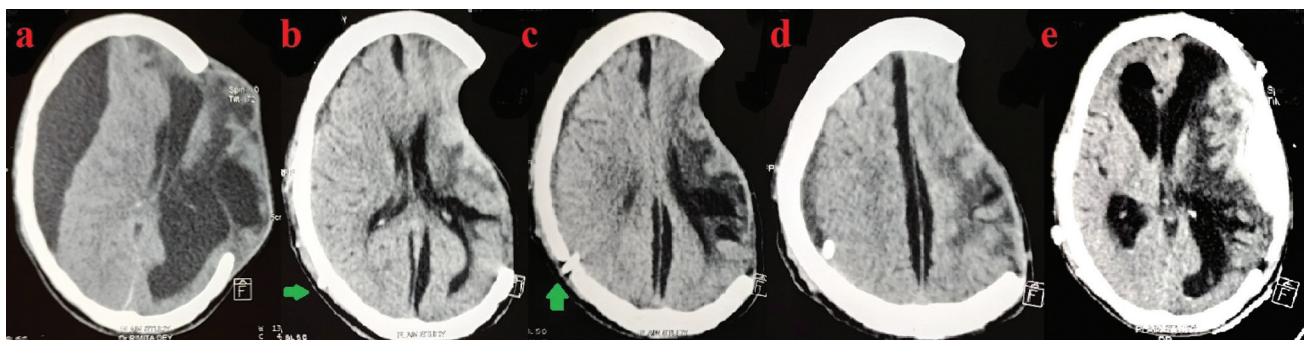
Pre-CP axial CT scan image (A) of a patient operated for left-sided acute subdural hematoma and contusions showing contralateral (right sided) hygroma with external cerebral herniation and midline shift; Axial images (B–D) showing concave flap after placement of a subduroperitoneal shunt and (E) extradural hemorrhage below the replaced flap after CP.
